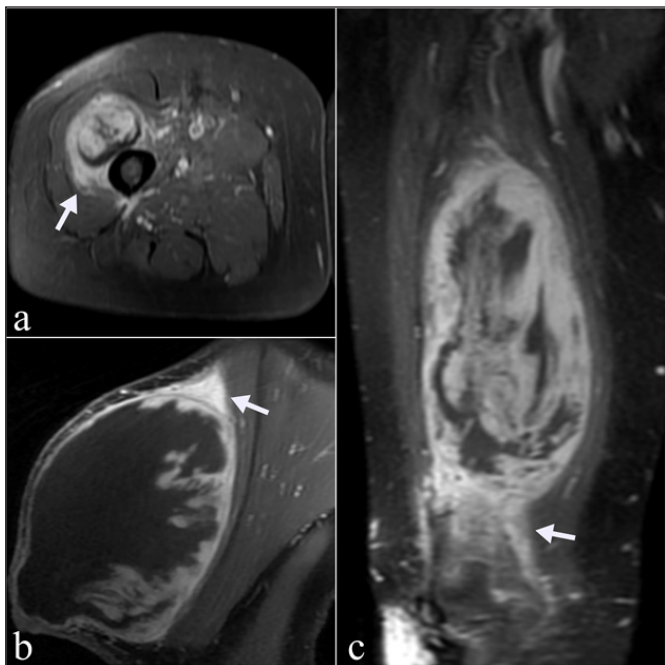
Peritumoral enhancement is more common in high-grade tumors. a. In the thigh MRI of a 62-year-old female patient, pleomorphic sarcoma and peritumoral enhancement were shown with an arrow. b. In the shoulder MRI of a 33-year-old male patient, fibrosarcoma and peritumoral enhancement were shown with an arrow. c. In the thigh MRI of a 67-year-old female patient, undifferentiated pleomorphic sarcoma and peritumoral enhancement were shown with an arrow.
